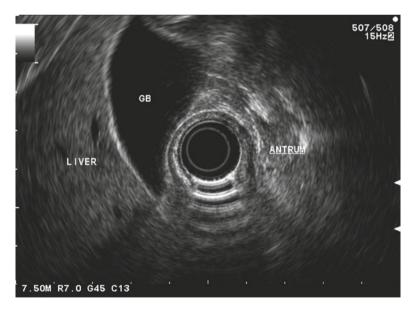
Ultrasound image from the prepyloric antrum demonstrating the gall-bladder (GB) and liver.
